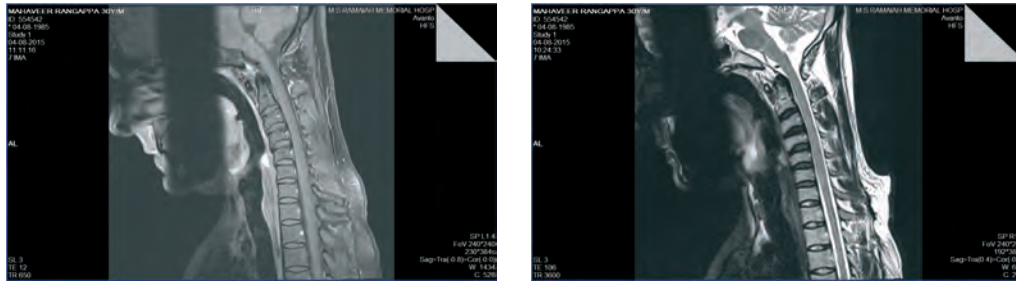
MRI studies of the cervical spine in flexion failed to demonstrate the typical changes associated with Hirayama disease.
